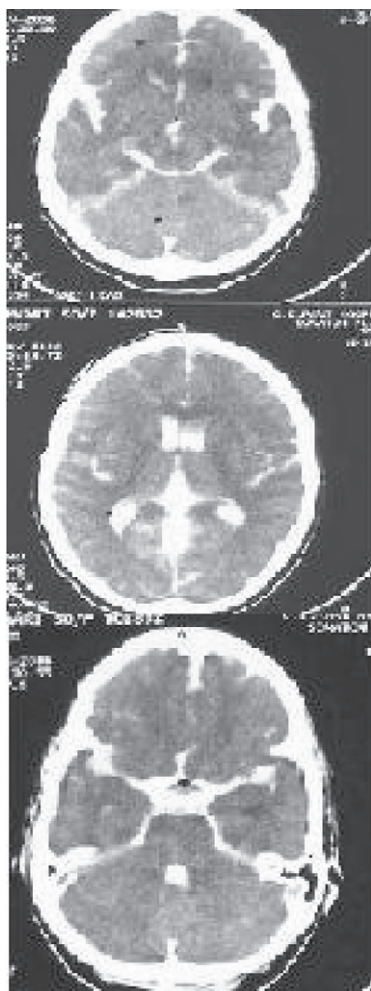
Non-contrast CT head showing hyper-density in all the cisterns and ventricles.
